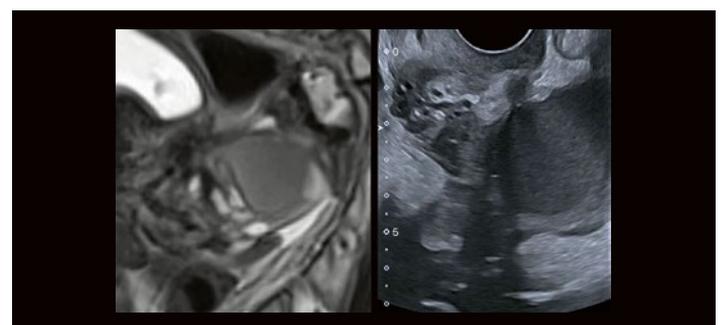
MRI and ultrasound parasagittal planes: posterior nodule.
